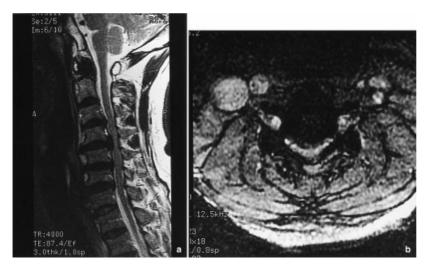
MRI of the cervical spine. (a) T2-weighted sagittal-section image reveals degenerative change with multiple disc bulging at C3–C7. (b) Axial view at the C4–5 level reveals severe cord compression resulting from disc bulge
